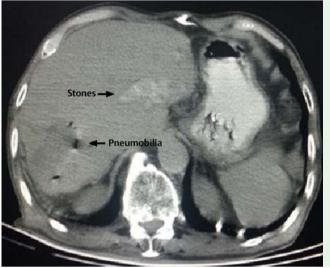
Computed tomography reveals pneumobilia and intrahepatic stones in an 89-year-old man with fever of 3 days' duration and symptoms of cholangitis and cholelithiasis. The patient had undergone cholecystectomy and common bile duct exploration 30 years previously because of gallstone disease.
